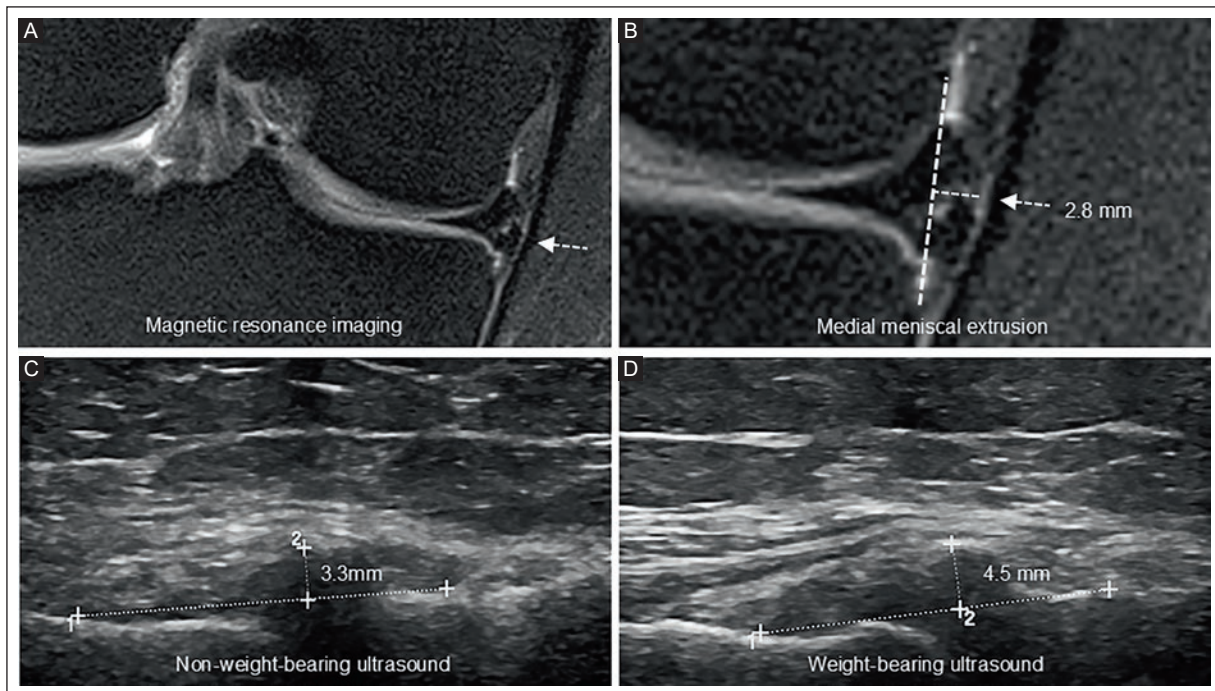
Comparison of imaging modalities of the medial meniscus in a 58-year-old obese man (BMI 31.5 kg/m<sup>2</sup>) with right knee pain. A-B: coronal proton density-weighted MRI with fat suppression shows minor medial meniscal extrusion of 2.8 mm. C: NWB-US shows a major 3.7 mm medial meniscal extrusion. D: WB-US shows a major 4.6 mm medial meniscal extrusion.
